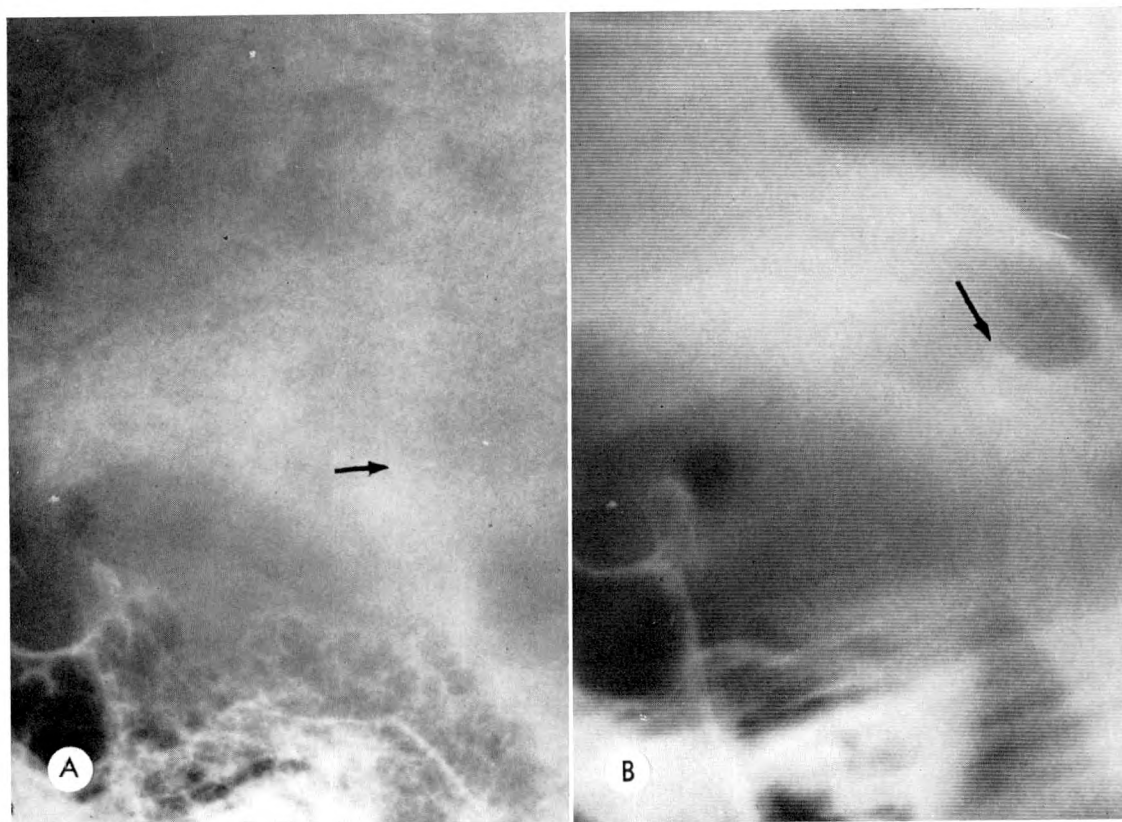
Linear habenular calcification shown on (A) the plain skull roentgenogram and on (B) the pneumoencephalogram (autotomogram).
